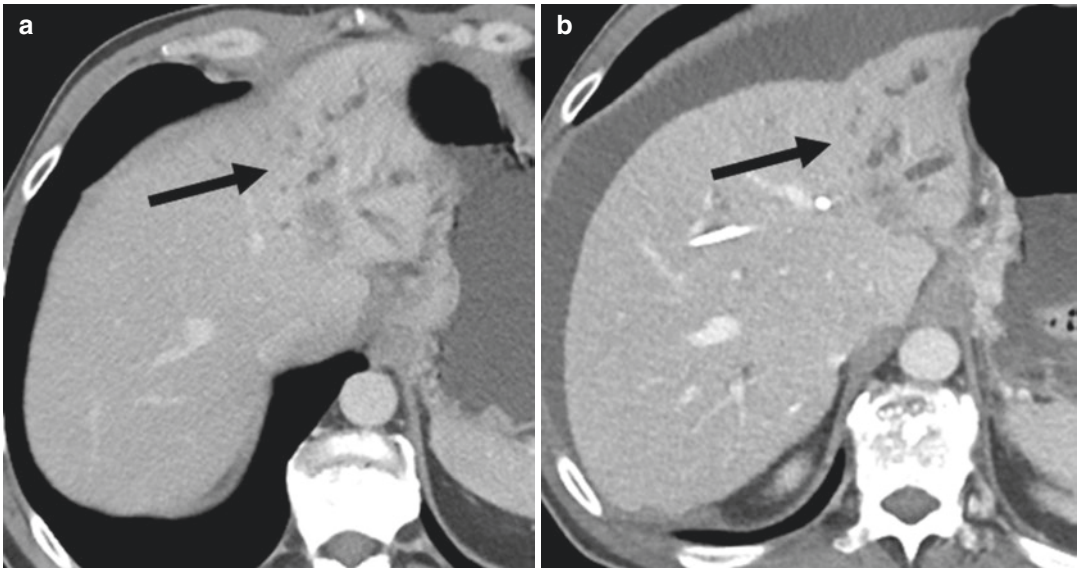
Cholangiocarcinoma at baseline (arrows) (a) and 2 months after chemotherapy (b) on CT shows minimal change in tumor size and enhancement in response to chemotherapy
